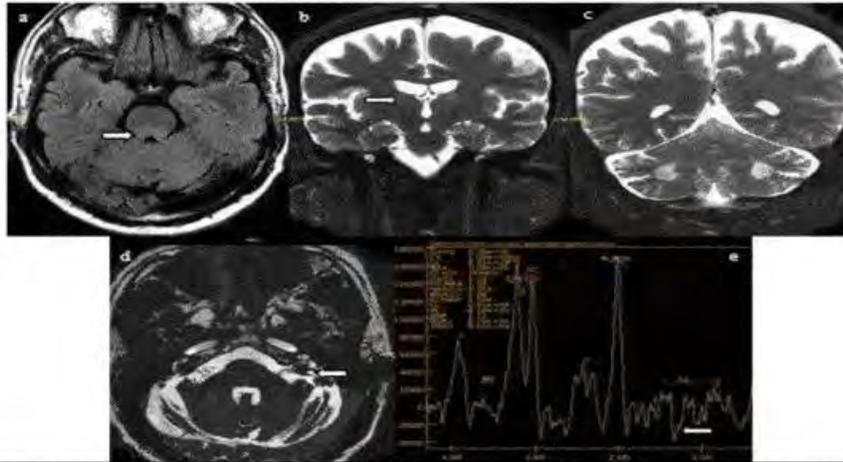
MRI in POLG mutation (MIRAS syndrome): Images depict thalamic, posterior brainstem, cerebellar involvement with prominent lactate in MRS.
